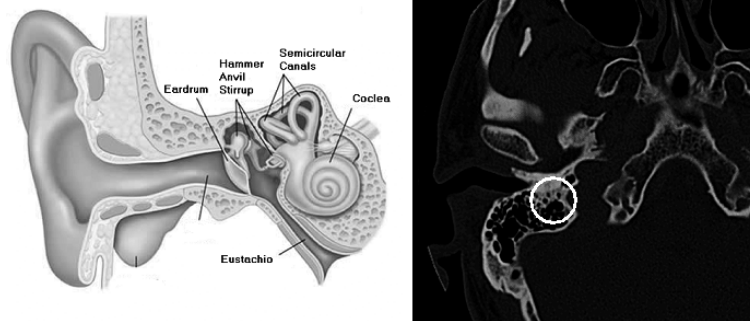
Scheme of ear anatomy (left) and tomographic image (right) of the inner ear (inside the circle) obtained by means of a standard medical CT scanner: the contrast is good, but the anatomy of the labyrinth and other parts of the inner ear is poorly defined.
